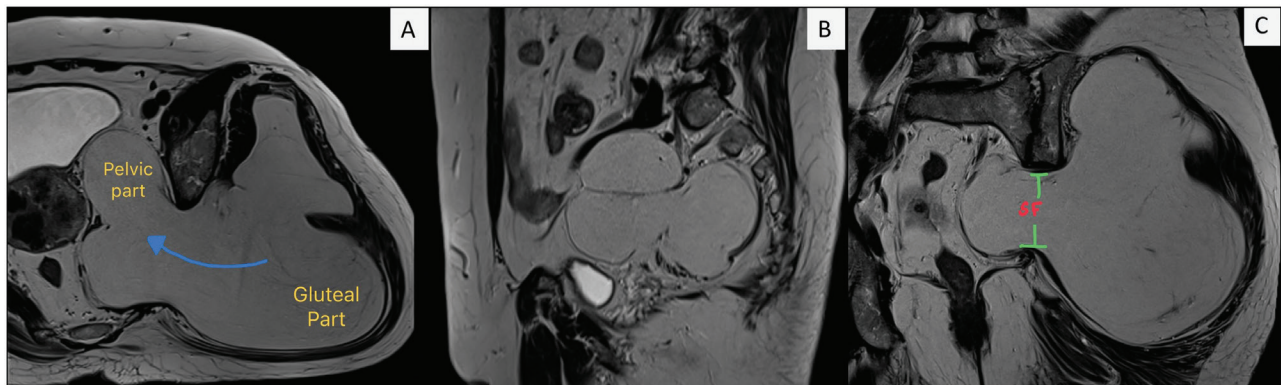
MRI of inverse sciatic hernia of the gluteal mass. T2-weighted images of (A) axial, (B) sagittal, and (C) coronal sections, respectively. Blue arrow showing the direction of hernia from the gluteal region to the pelvis via sciatic foramen. SF = sciatic foramen
